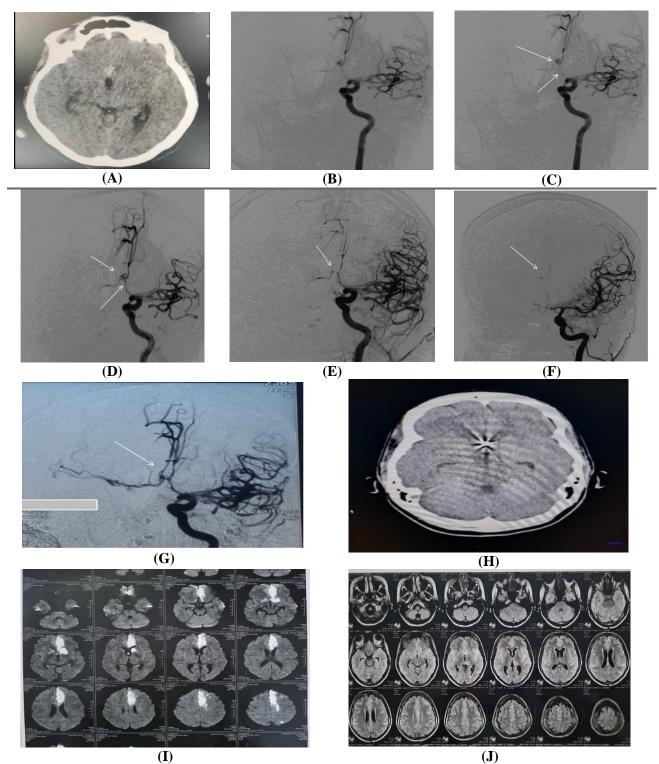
(A): CT brain showing blood in the subarachnoid space, (B): Cerebral diagnostic angiography showed anterior communicating artery aneurysm, (C): Before injection of intraarterial nimodipine, (D): After injection of intraarterial nimodipine, (E): Coiling of the aneurysm, (F): Blood clot formed leading to decrease flow in anterior cerebral, (G): After injection of integrillin and resolution of the blood clot, (H): Post-operative CT, (I): Post-operative MRI, (J): MRI follow up after 3 months showing resolution of ischemia.
